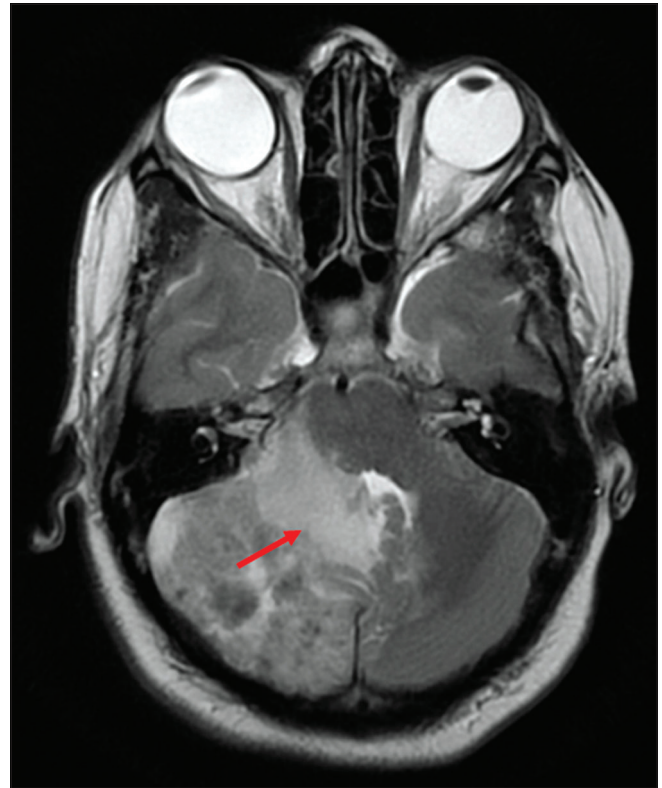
MRI showing right cerebellar space occupying lesion causing mass effect on brainstem and vermis. This leads to a mass effect over fourth ventricle and aqueduct of sylvius causing obstructive hydrocephalus of lateral and third ventricle
